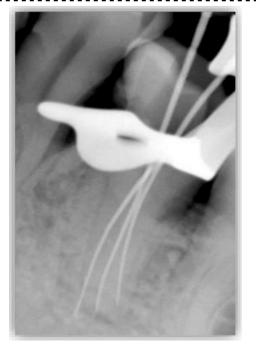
Working length Radiograph showing three separate canals
